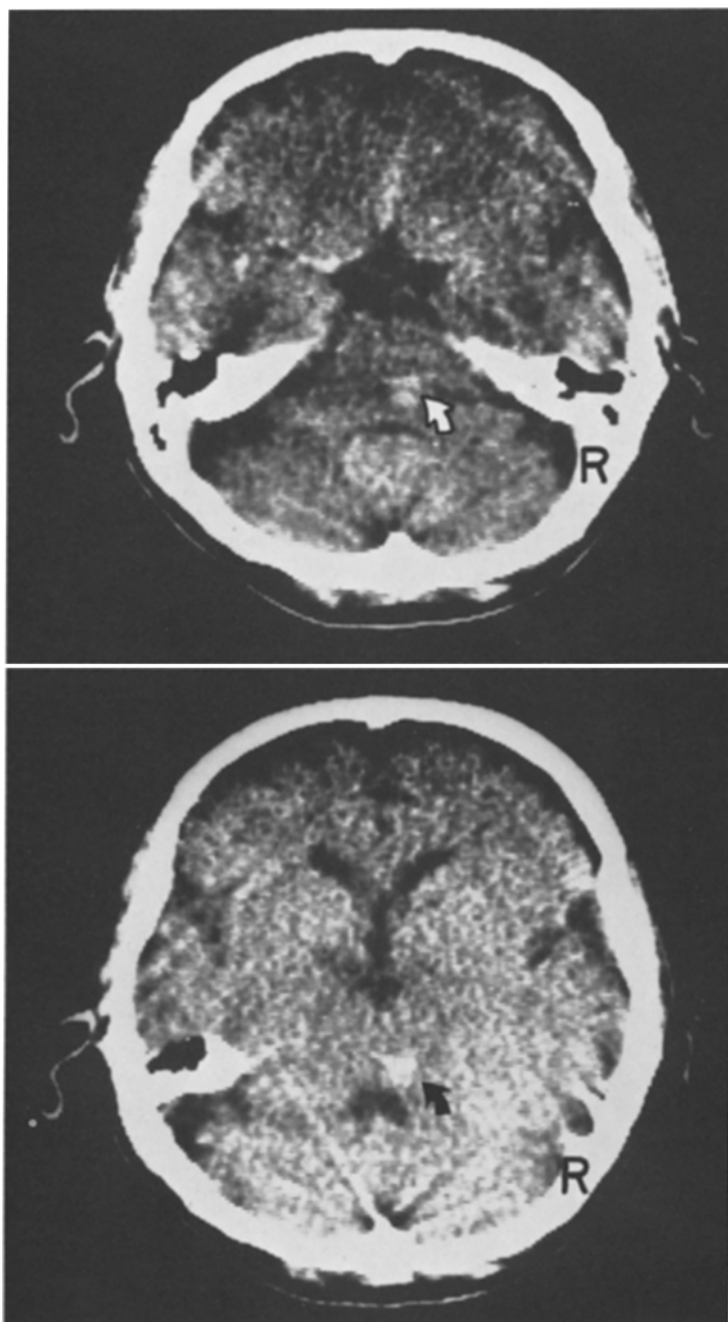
CT of the posterior fossa (axial view, unenhanced). A haematoma is clearly seen in the pons (*arrow*), involving the posterior part on the right, just below the floor of the fourth ventricle. The diameter of the haematoma is 2.5 cm
